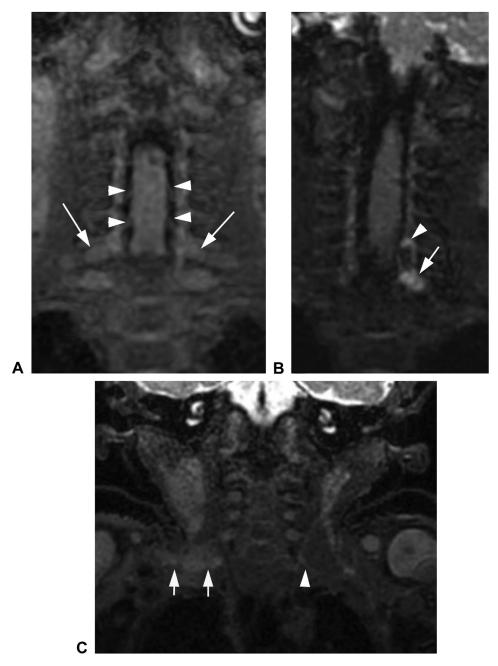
Representative examples of typical MRI finding using the coronal 3-dimensional PD MRI sequence. A Normal preganglionic nerve roots (arrowheads) and a normal dorsal root ganglion (arrows). B Left C7 (arrowhead) and C8 (arrow) pseudomeningoceles and avulsed nerve roots. C Right C5 and C6 nerve postganglionic ruptures with neuromas at the trunk level (arrows), with normal left C6 postganglionic nerve appearance (arrowhead).
